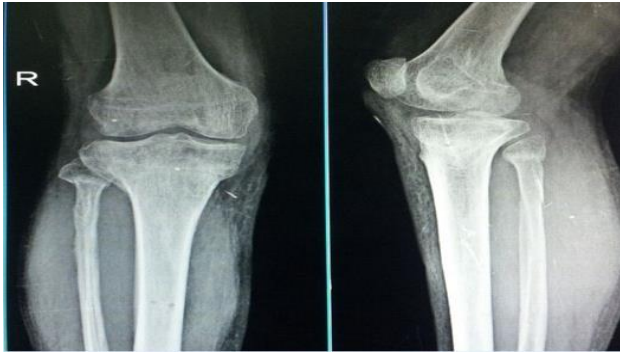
Radiographs at union, showing a well aligned knee joint.
